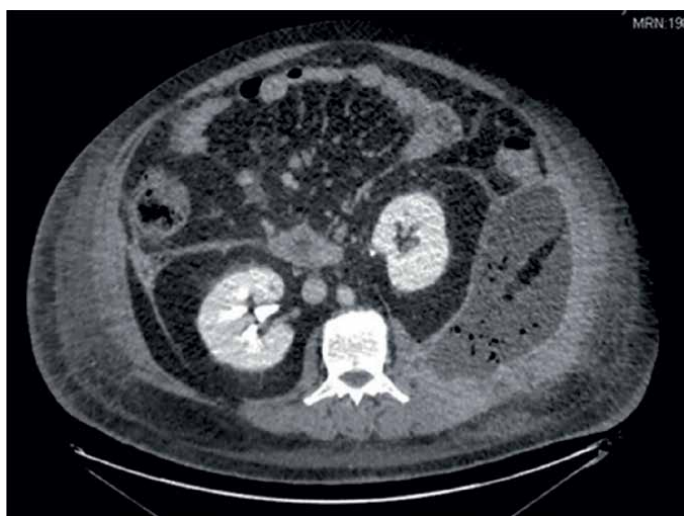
CT scan revealing a left retroperitoneal collection, which is easily accessible for percutaneous drainage and permits a retroperitoneal laparoscopic approach.
